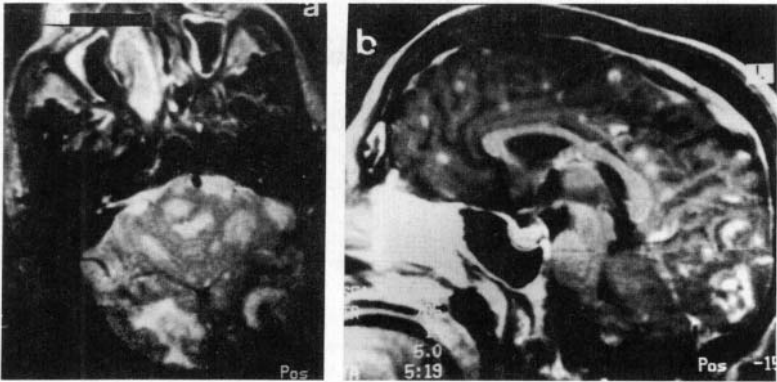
Toxoplasmosis. T2 axial image (a) showing multiple lesions with perifocal edema. Lesions in the occipital region are predominantly hypointense. Postcontrast T1-weighted sagittal image (b) shows multiple enhancing lesions of varying sizes.
